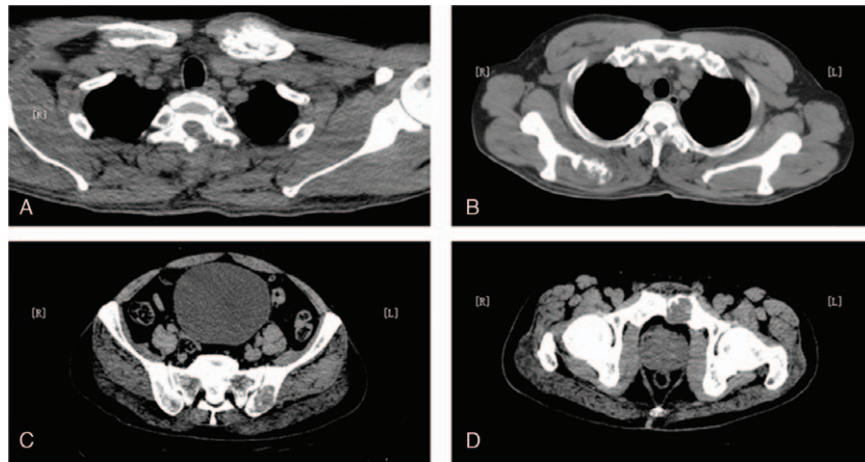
Computed tomography images of multisite bone destruction. (A) Left clavicle bone destruction; (B) right scapula bone destruction; (C) left iliac bone destruction; (D) left pubic bone destruction.
